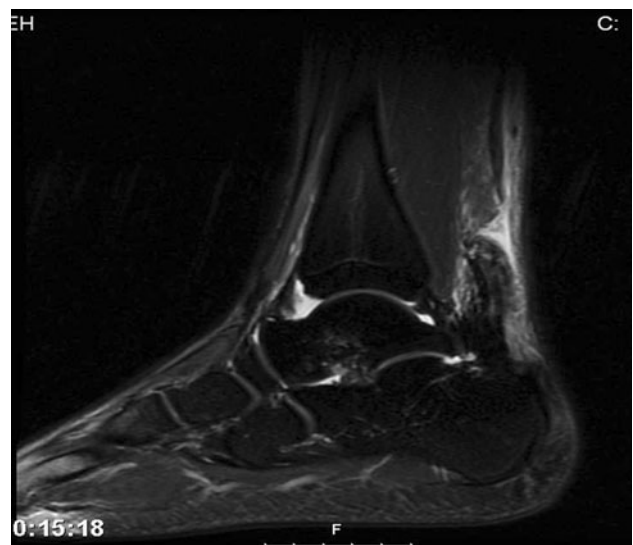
Observation of an Achilles rupture with patient in prone position. Arrow indicates rupture and loss of plantarflexion at restFig. 3 Magnetic resonance imaging of AT rupture (sagittal view). Arrow indicates area of rupture
